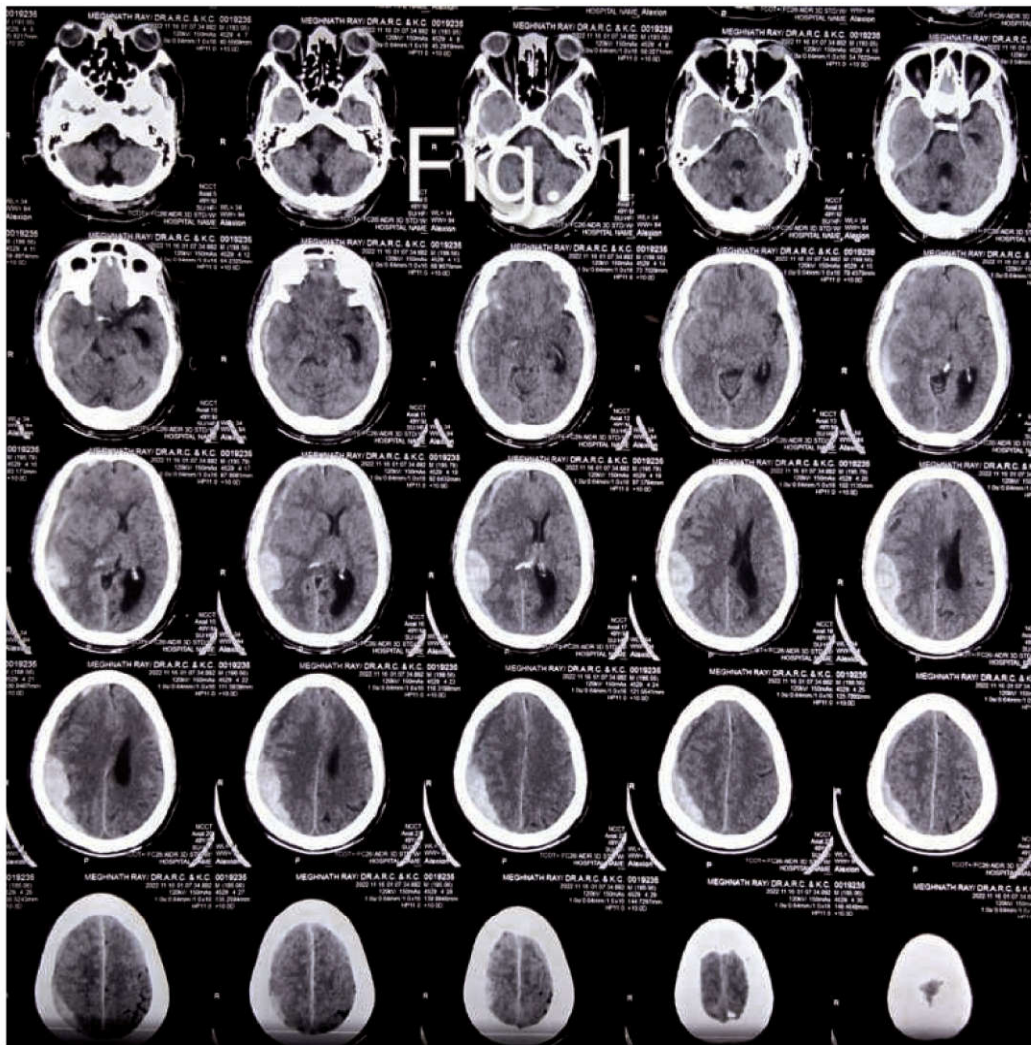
CT scan after conservative tx.
